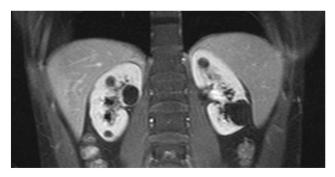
MRI scan confirms bilateral multiple cysts: at least six cysts in the left and four in the right kidney. The cysts are localized in the renal parenchyma, mainly in the cortex, and they have a benign simple appearance (Bosniak category I). The largest cyst has a diameter of 3 cm.
